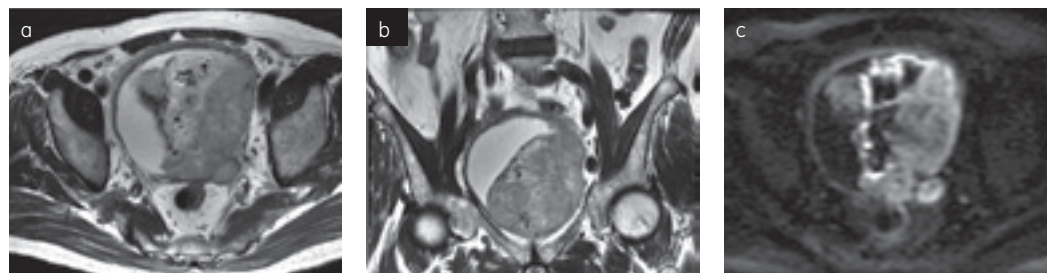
Urinary bladder cancer. (a) Transverse T2WI. (b) Coronal T2WI. (c) DWI (b-value 1500 s/mm²).
